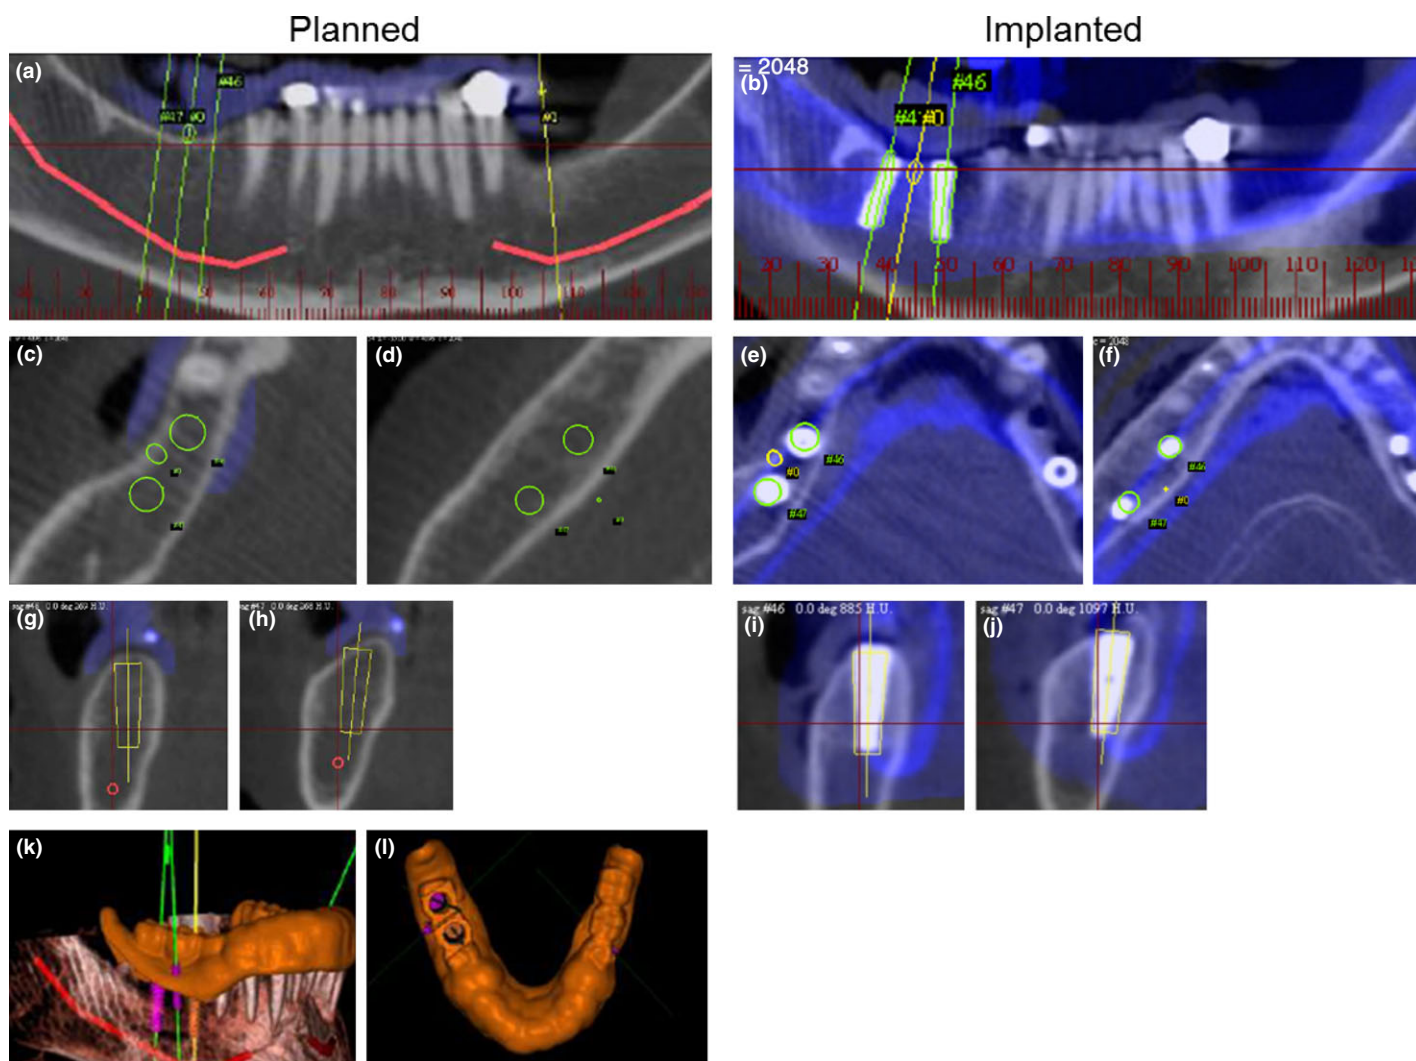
Case showing planned (a, c, d, g, h, k, l) and implanted (b, e, f, i, j) images of guided implant placement in the mandible. CBCT scans were taken of patients before (a) and after (b) implant placement, showing outline of planned implant (a, b) and location of actual implant (b). Cross-sectional slices for location analysis were performed for planned (c, d) and implanted (e, f) implants at the coronal (c, e) and apical (d, f) levels. Close-up images of each implant placed from original CBCT scans (a, b) are shown before (g, h) and after implantation (i, j). A 3D reconstructed view of the mandible with surgical guide (k, l) was used for implant placement.
